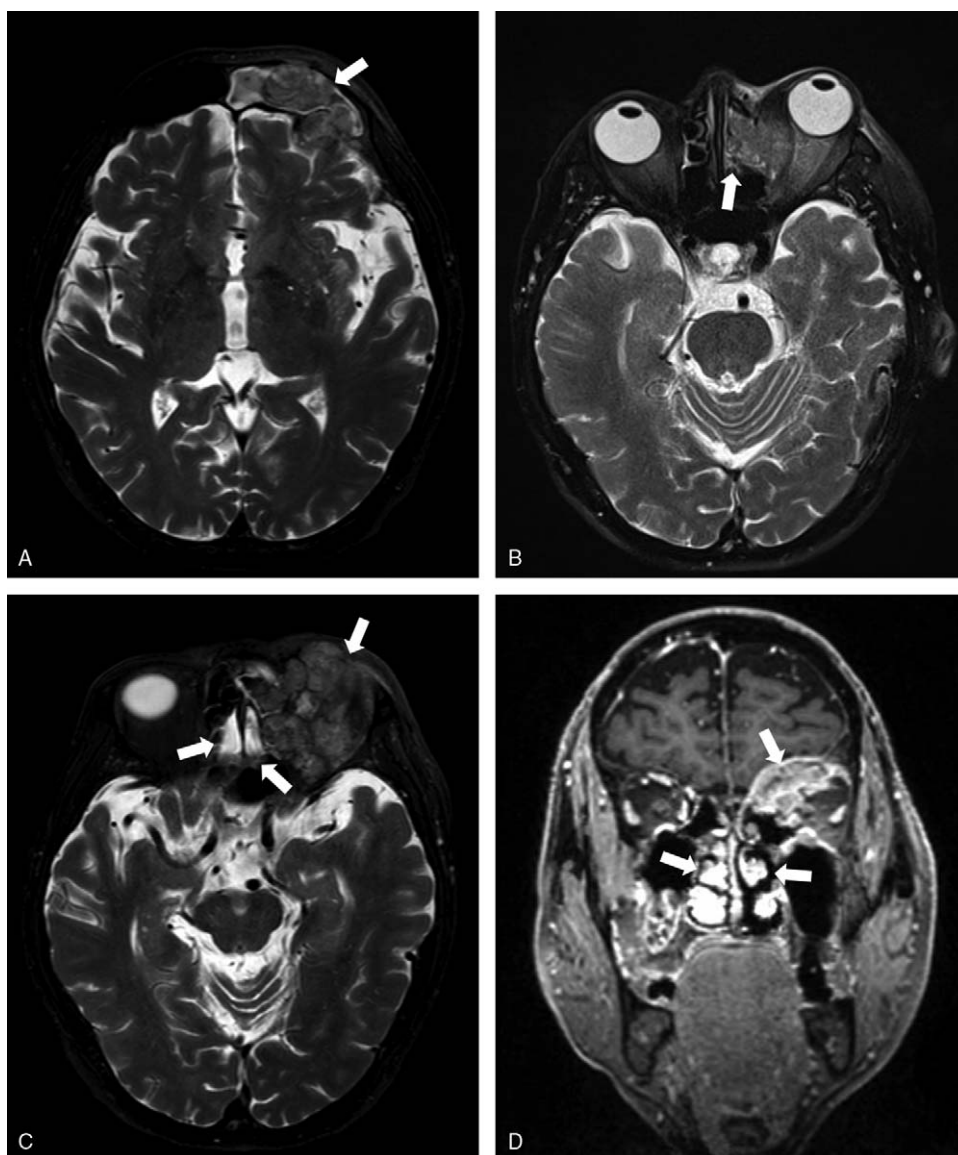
Magnetic resonance imaging of left ocular region. White arrows indicated the lesions. (A) Soft tissue mass in left frontal sinus, transverse section; (B) soft tissue mass in medial wall of left orbits and left ethmoid sinus, transverse section; (C) soft tissue mass in the bottom of left orbits and bilateral ethmoid sinus, transverse section; (D) soft tissue mass in bilateral ethmoid sinus, coronary section.
